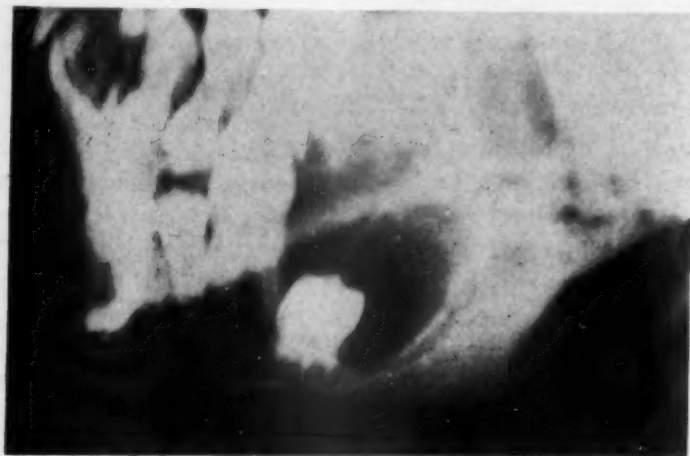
X-ray of the jaw of a patient with generalized osteomyelitis showing enlargement of the condyle.
